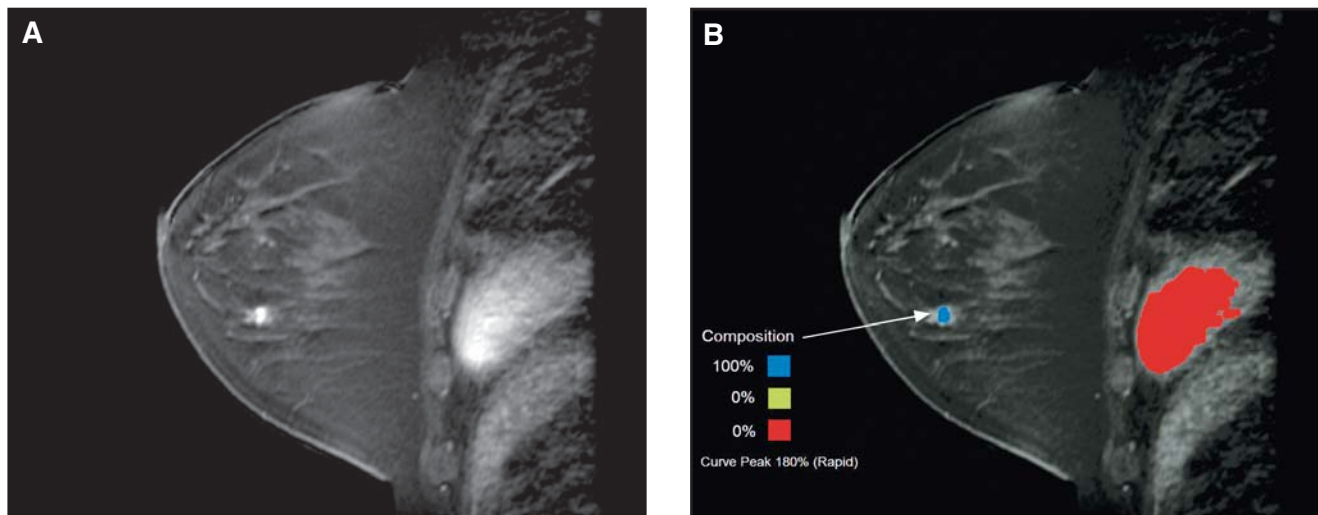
Magnetic resonance (MR) images of a newly diagnosed carcinoma in the left breast at 6 o'clock. A. Sagittal, fat-suppressed, T1-weighted, 3-D spoiled gradient recalled immediate postgadolinium image demonstrates an additional enhancing irregular mass at 3 o'clock. B. Same image with computer-aided evaluation (CAE) applied demonstrates the lesion meets the minimum enhancement threshold of 100%, indicated by the presence of color overlay at the site. CAE-generated enhancement synopsis in the lower left demonstrates the lesion enhancement profile (arrow) with 100% persistent enhancement. CAE-generated initial peak enhancement is also displayed. The lesion also met the enhancement threshold of 50% (not shown). MR biopsy demonstrated infiltrating ductal carcinoma, confirming multicentric malignancy. (Image courtesy of Wendy DeMartini, M.D., University of Washington Medical Center, Seattle, Wash. From: DeMartini W, Williams T, Lehman C, Peacock S, Partridge S. Analysis of a computer-aided evaluation program for breast MRI in discriminating benign from malignant lesions [abstract]. RSNA. 2005; SSM01-03.)
